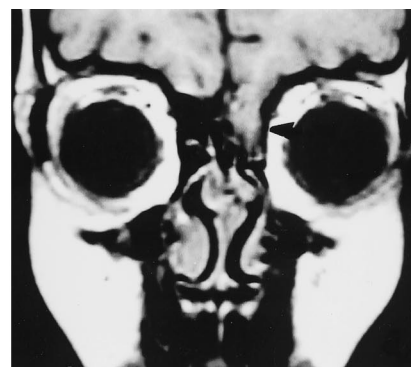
T1-weighted coronal MR image shows presence of herniated gyrus rectus through the left cribriform plate and fovea ethmoidalis (arrowhead).
